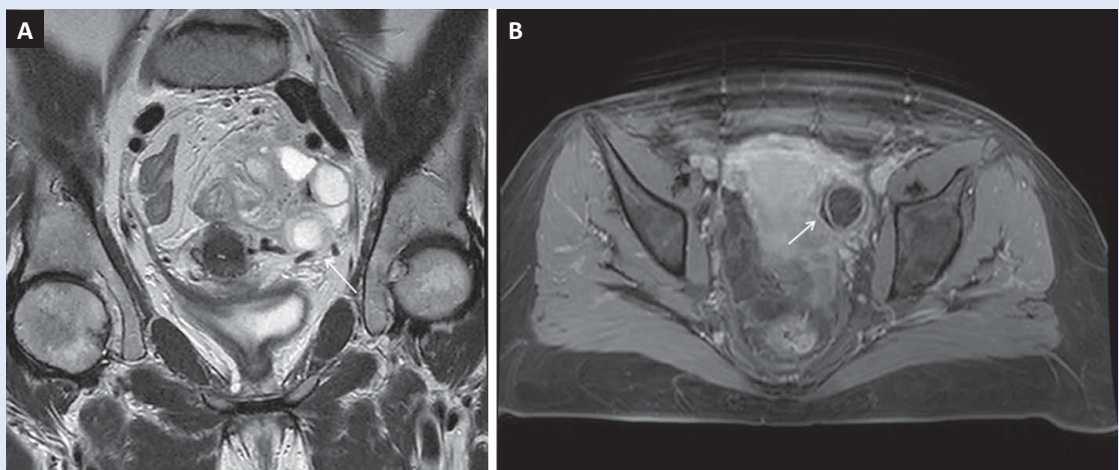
MRI images of a dilated fallopian tube (A – coronal plane, T2-weighted image; B – axial plane, T1-weighted contrast-enhanced image).
